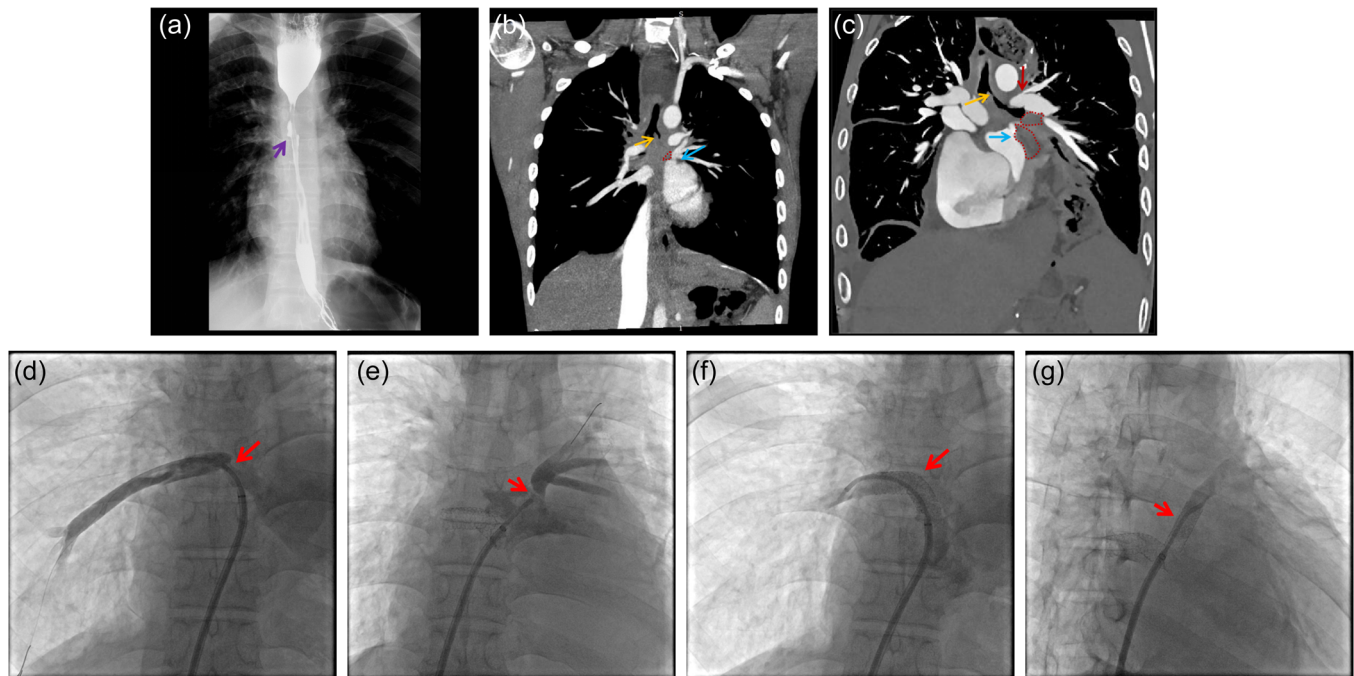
(a) Barium meal radiography shows an esophageal fistula 6 years ago (purple arrow). (b) Enhanced computed tomography 6 years ago showed stenosis of pulmonary vein (blue arrow) and bronchus (yellow arrow) compressed by proliferative fibrotic tissues (red dots) in mediastinum. (c) Computed tomography pulmonary angiography demonstrated stenosis of left superior pulmonary vein (blue arrow), left superior pulmonary artery (red arrow) and bronchus (yellow arrow) compressed by proliferative fibrotic tissues (red dots) in mediastinum. Thoracic stomach also can be found. (d) Selective pulmonary vein angiography showed right inferior pulmonary vein stenosis (red arrow). (e) Selective pulmonary vein angiography showed left superior pulmonary vein stenosis (red arrow). (f) Selective pulmonary vein angiography showed stenting in the right inferior pulmonary vein stenosis (red arrow). (g) Selective pulmonary vein angiography showed stenting in the left superior pulmonary vein stenosis (red arrow).
